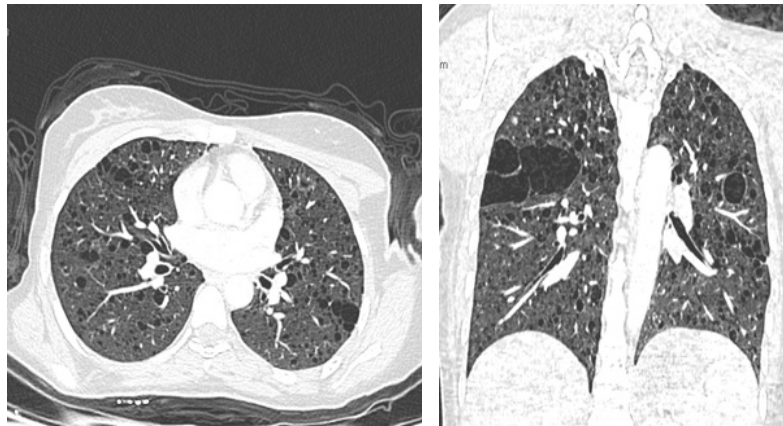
Chest CT scan in parenchymal window, in axial and coronal slices, showing multiple diffuse bilateral pulmonary cystic lesions in both lung fields, some of which are confluent, suggestive of thoracic lymphangioleiomyomatosis.
